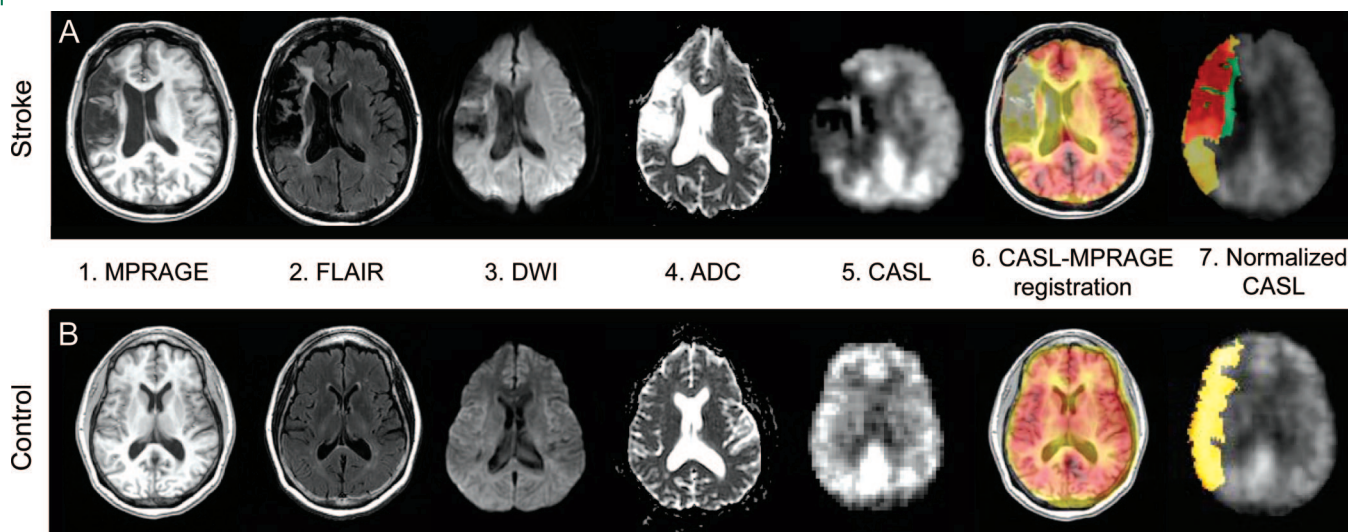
is an example of perfusion image registration on anatomic images for a subject with right MCA territory infarctions (A) and a control (B). The perfusion CASL image<sup>5</sup> and anatomic MP-RAGE image<sup>1</sup> are coregistered<sup>6</sup> and normalized to standard template.<sup>7</sup> The infarct (red) and PIHs (green) on the structural images,<sup>1,2</sup> DWI,<sup>3</sup> and apparent diffusion coefficient (ADC) map derived from DWI<sup>4</sup> and MCA territory (yellow) are normalized and overlaid on normalized CASL.<sup>7</sup>
